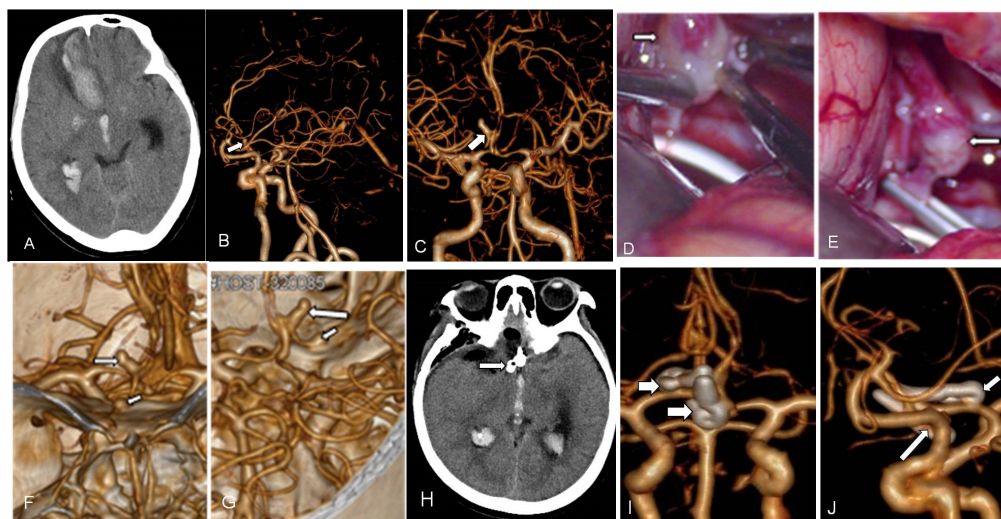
[A] Preoperative CT scan reveals a hematoma in the right frontal gyrus rectus, hematocoele in ventricles and subarachnoid space. On preoperative 3D CTA with bone subtraction imagings, anteroposterior; [B] and lateral [C] there is a saccular aneurysm located on the A2 segment of the right cerebral anterior artery (arrows). Intraoperative photographs; [D] and [E] demonstrate a fusiform aneurysm of orbital frontal artery and yellow arachnoid membrane on the aneurysm wall (arrows). On preoperative 3D CTA without bone subtraction imagings, anteroposterior; [F] and lateral [G] there are two aneurysms (arrows); [H] Postoperative CT scan shows the position of the two clips(arrow). On postoperative 3D CTA with bone subtraction imagings, anteroposterior; [I] and lateral [J] there are two clips (arrows) and no aneurysms were shown.
